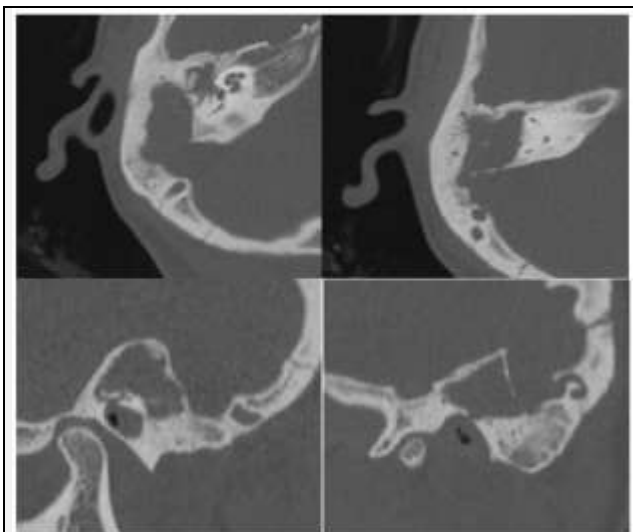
Chronic Suppurative Otitis Media. High Resolution CT Axial and Coronal Scan of Right Side Shows Soft Tissue Density Material Occupying Right Middle Ear Cavity with Loss of Ossicular Chain, Mastoid Air Cells and Sigmoid Sinus Plate.
